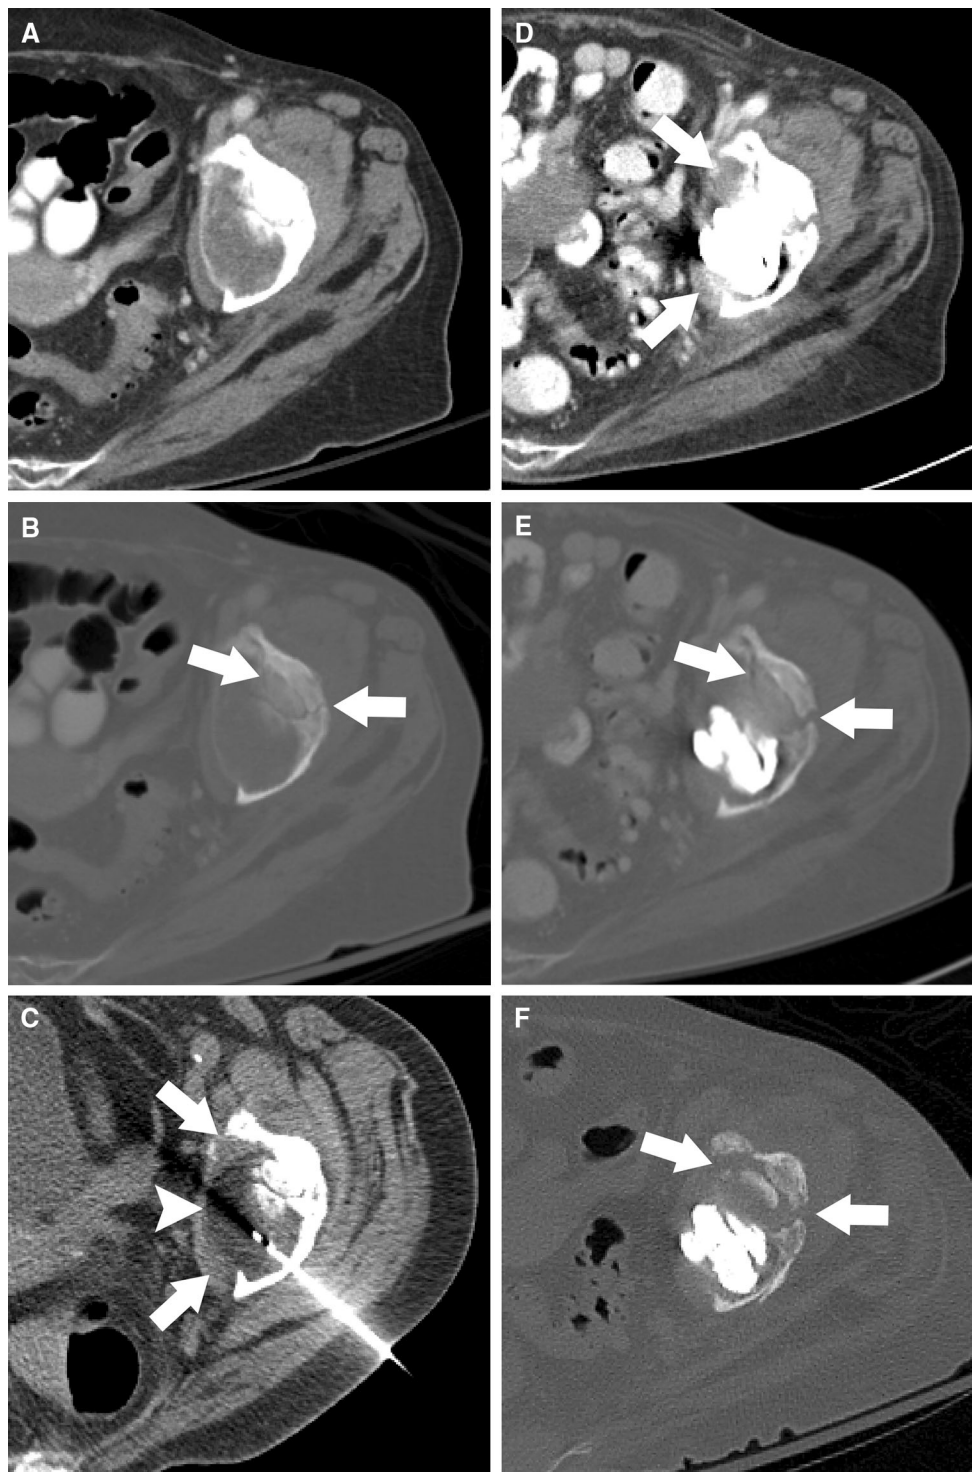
Incomplete cryoablation and cementoplasty for pain and fracture risk reduction. A A 71-year-old woman with a 5.6 cm osteolytic renal cell carcinoma metastasis to the left acetabulum presented for treatment of pain, scored as 10/10. B Pre-procedural CT showed a nondisplaced pathologic fracture (arrows). C Ablation zone (arrowhead) covered most of the tumor during cryoablation, with a small amount of tumor left untreated anteriorly and posteriorly
